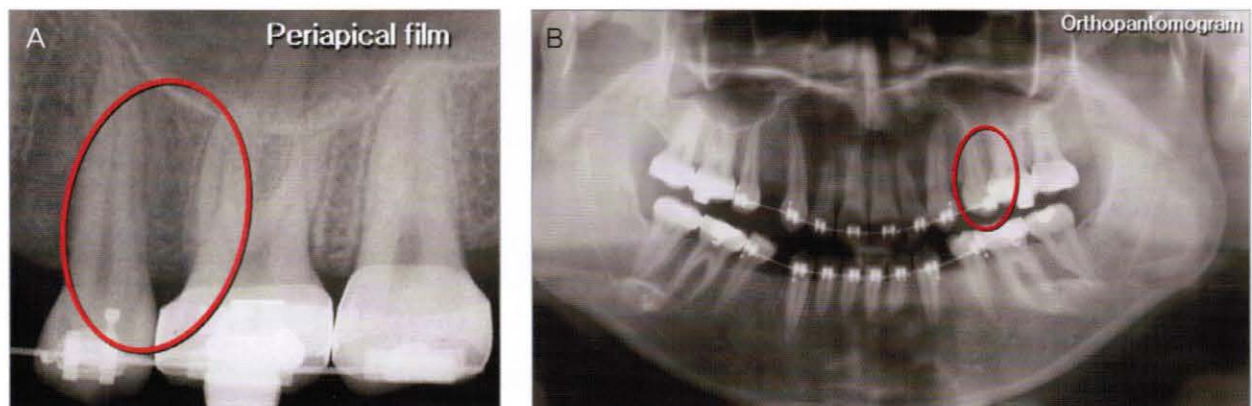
A periapical radiograph is taken so that the contact points of adjacent teeth do not overlap (A). The panoramic radiograph is not accurate enough (B). Area with the circle shows that the adjacent teeth are shown overlapped.
